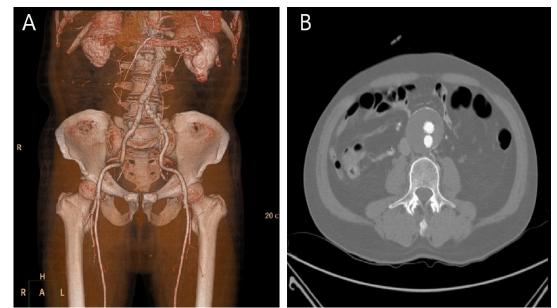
Computed tomography (CT) showing a successful endovascular aneurysm repair (EVAR) (A) without any evidence of an endoleak (B)
